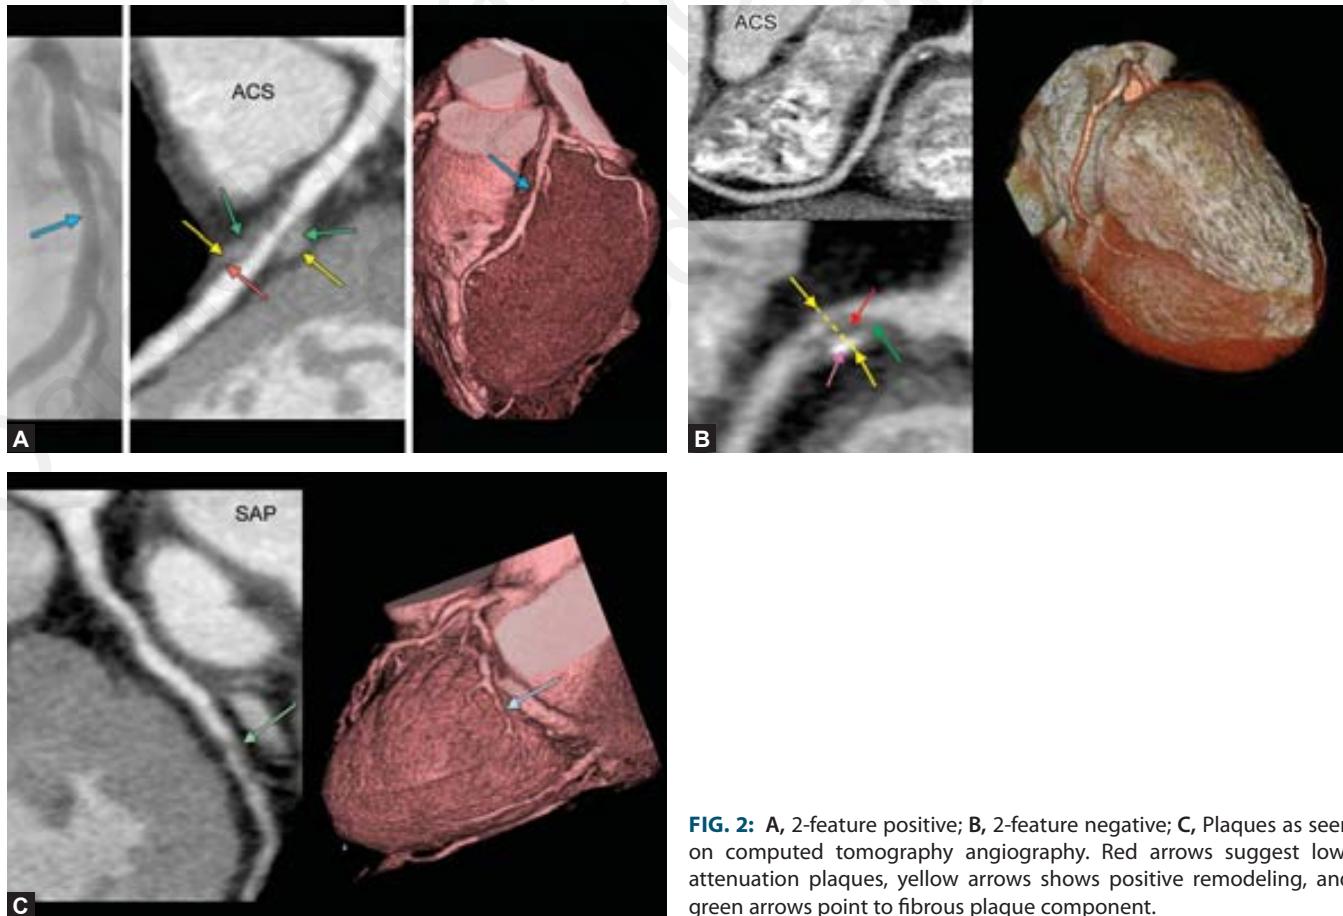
A, 2-feature positive; B, 2-feature negative; C, Plaques as seen on computed tomography angiography. Red arrows suggest low-attenuation plaques, yellow arrows show positive remodeling, and green arrows point to fibrous plaque component.
